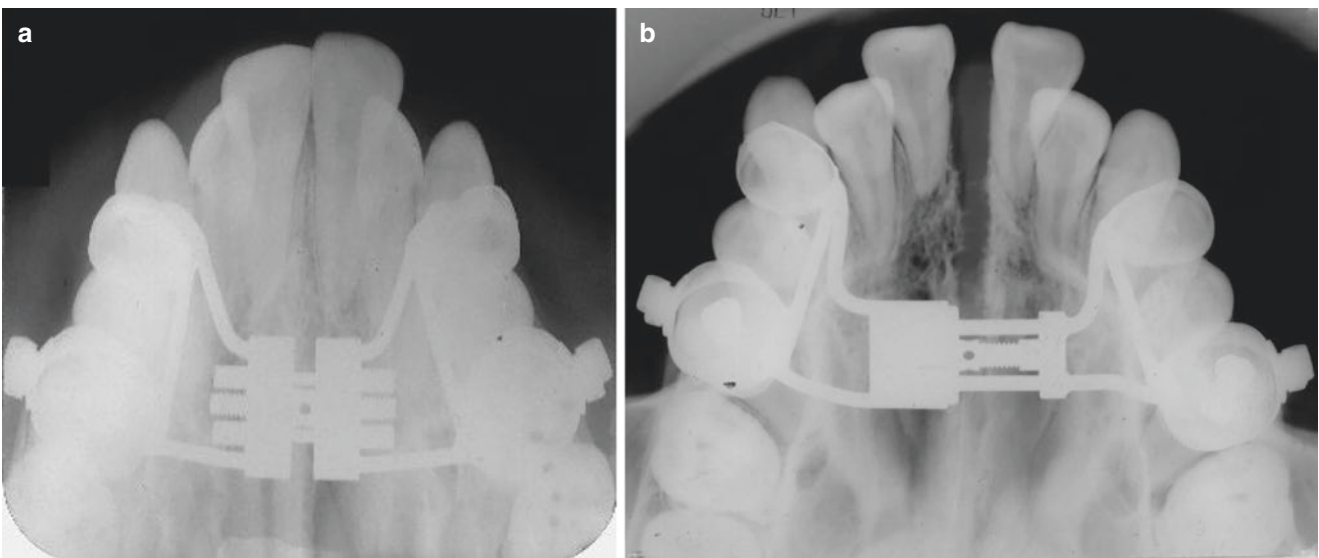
(a and b) Pre- and post-occlusal radiographs after the use of a rapid maxillary expander for 2 weeks
